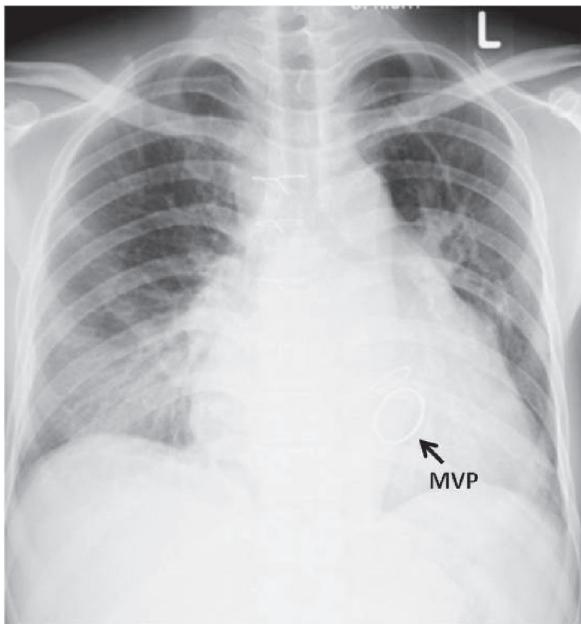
Chest X-ray showing cardiomegaly with pulmonary congestion and mitral valve prosthesis (MVP).
